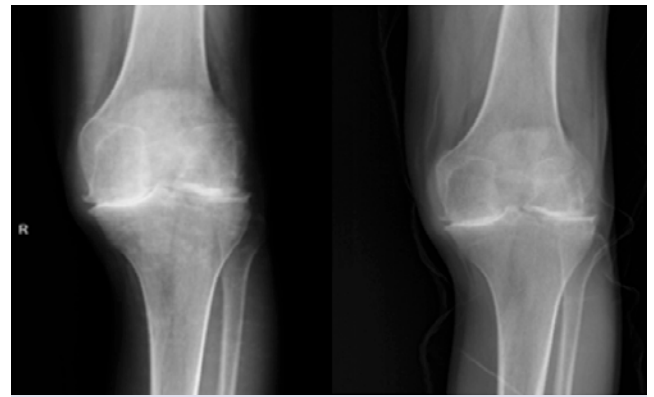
Right knee X-ray image at baseline and 1 year post-injection.
